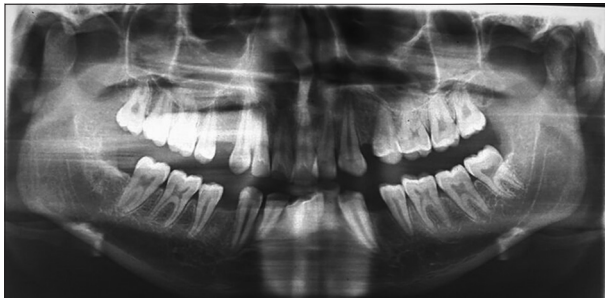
6-month post-operative orthopantomograph
